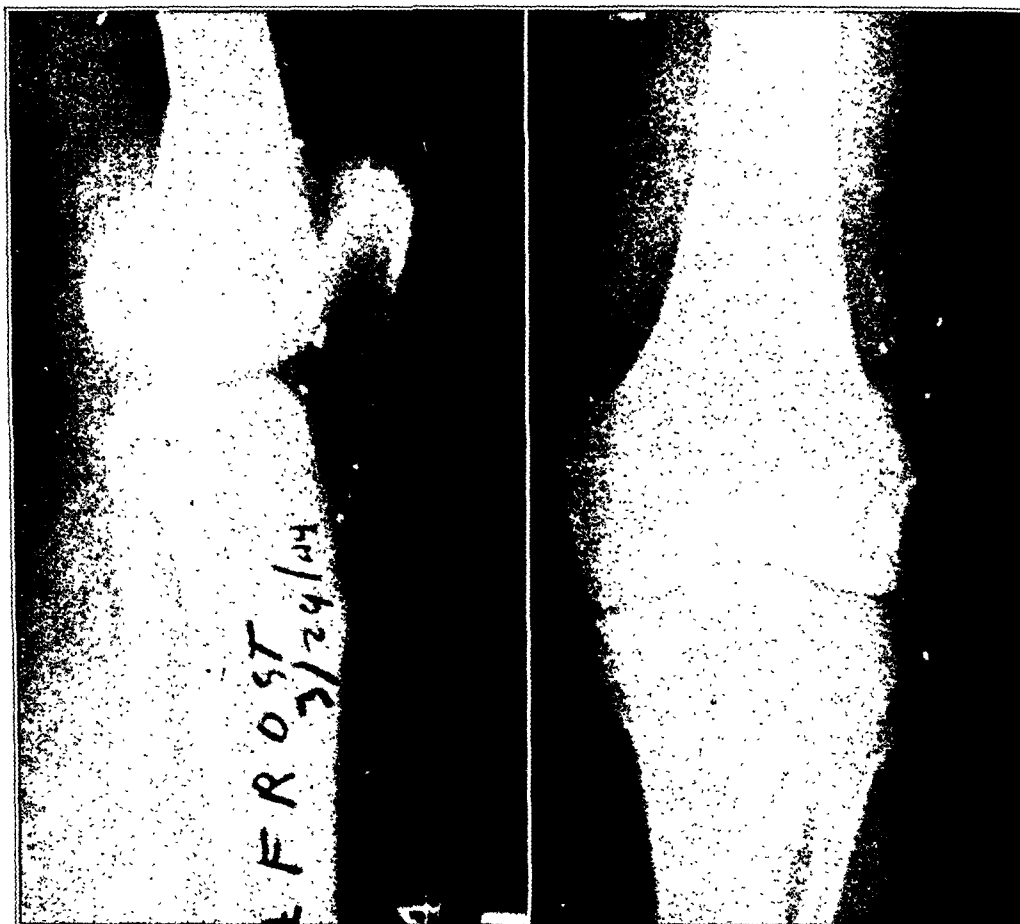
A, Case III. anteroposterior and lateral roentgenograms show the multiple foreign bodies in the joint.
